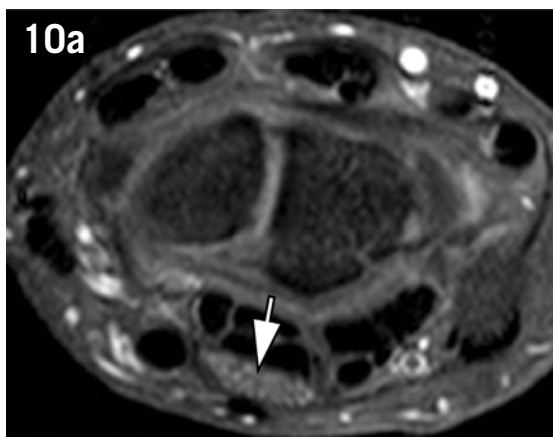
Carpal tunnel syndrome. Axial T2-weighted fat-suppressed images of the wrist at the levels of the pisiform (a) and the distal aspect of the carpal tunnel (b). Sagittal T2-weighted fat-suppressed image of the wrist shows the longitudinal axis of the median nerve (c). There is proximal enlargement (white arrow) and distal flattening (white arrowhead) of the median nerve. Note the increased signal and decrease in size with an "hourglass" appearance of the median nerve at the middle and distal aspects of the carpal tunnel (black arrowheads). There is also a thickening of the flexor retinaculum (black arrow).
